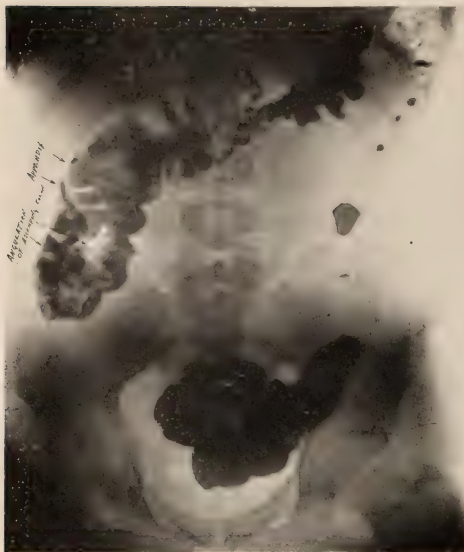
Cecum and portion of ascending colon apparently turned up and out upon upper portion of ascending colon. The appendix is seen near the hepatic flexure. Previous diagnosis of gall-bladder disease was made. Roentgenological diagnosis of appendicitis was verified. Relief was obtained. No attempt to correct location of the appendix was made, because it was apparently a case of arrested development. Potentially, it appears bad.
